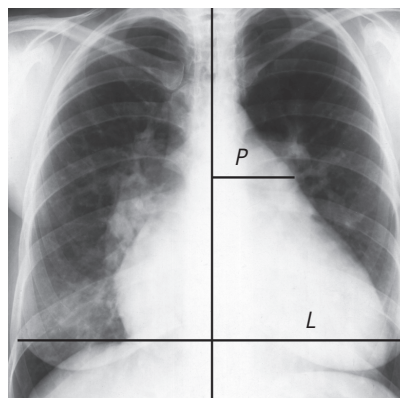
Frontal X-ray with the designation of the measurement for determination of the degree of the pulmonary artery expansion: *L* — half of the transverse basal size of the chest; *P* — the distance from the median line to the most distant point of the pulmonary artery border
